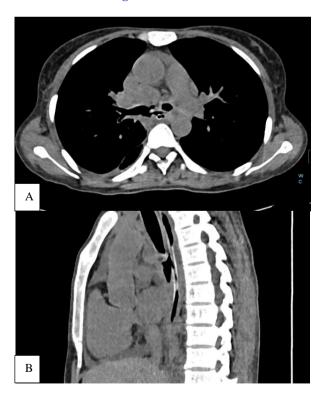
(A and B): HRCT showing fistulous tracts between the esophagus (with feeding catheter) and right main bronchus.
